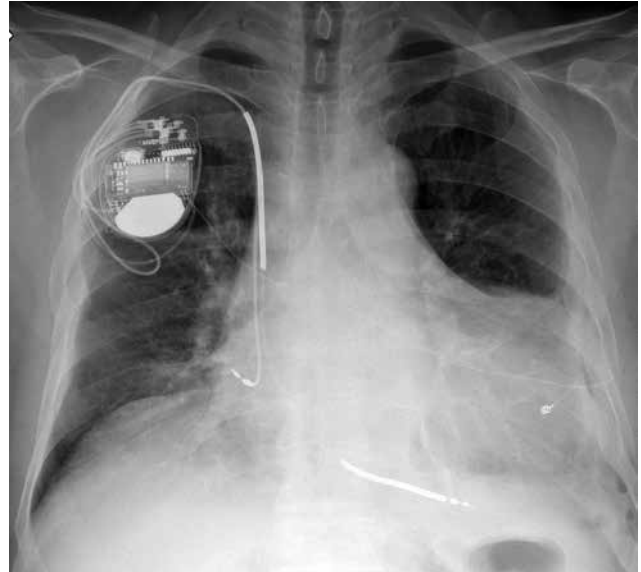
The position of the left ventricular lead confirmed by the postoperative chest X-ray.
